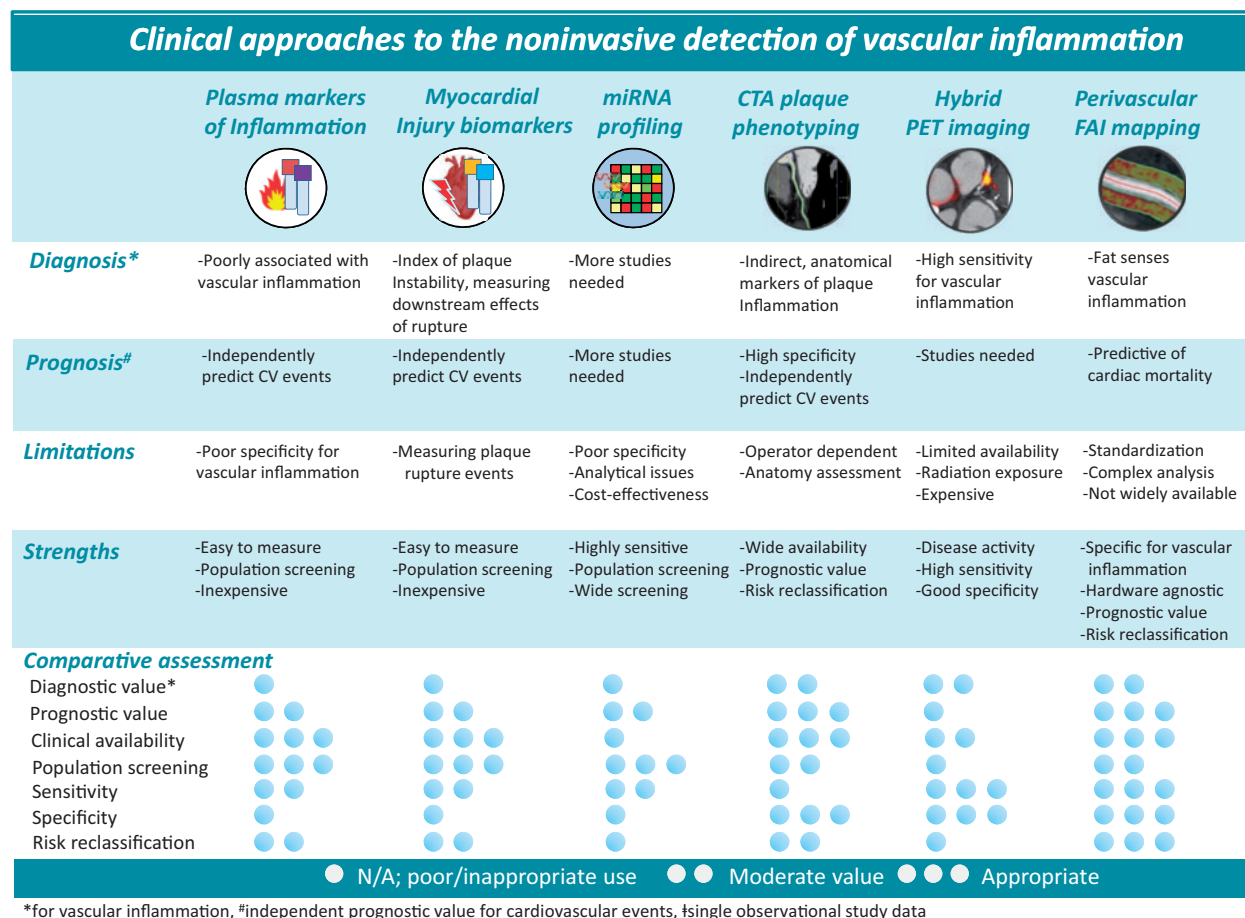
Overview and comparative assessment of existing approaches for the detection of coronary inflammation. CTA, computed tomography angiography; FAI, fat attenuation index; PET, positron emission tomography.
